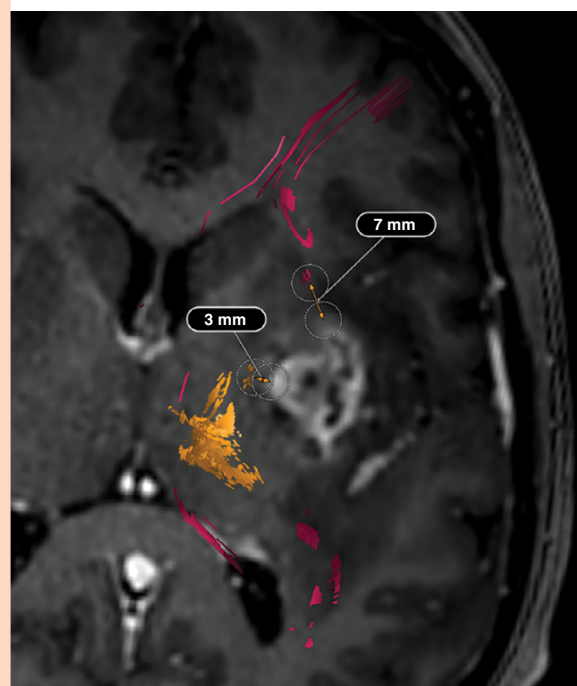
Linear measurement of distance between recurrence and eloquent fiber tracts. This figure displays the distance in mm between recurrence and eloquent fiber tracts (FT) on the left hemisphere. The corticospinal tract (CST) is displayed with a minimum distance of 3mm to the lesion and language FT with a minimum distance of 7mm. The imaging modality used was an MRI T1 contrast enhanced in the axial plane. The image was created using Brainlab Elements Viewer (version 5.2, Brainlab AG).
